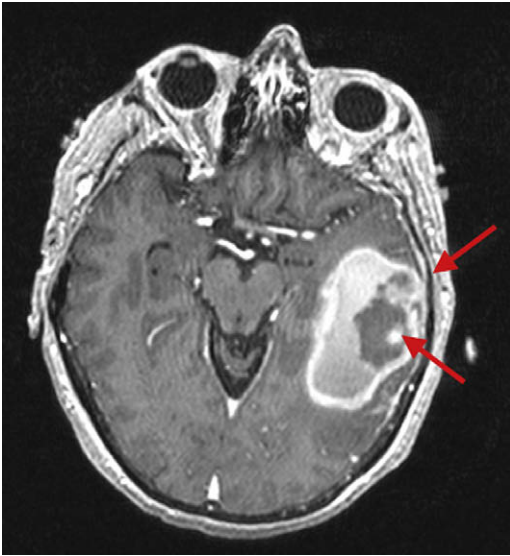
Contrast-enhanced T1-weighted MRI image demonstrating an enhancing nodule (arrows) associated with an intracerebral hematoma.
